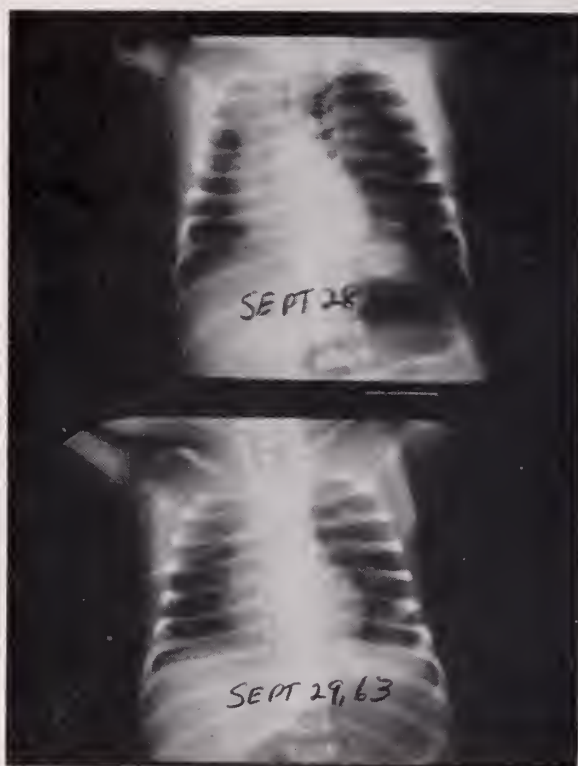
Roentgenograms demonstrating a massive pneumothorax on the left. The mediastinum is shifted to the right hemithorax. In the second film note a linear radio opaque object outside the chest wall; this is the needle of a plastic intracath attached to underwater drainage. The infant recovered.
